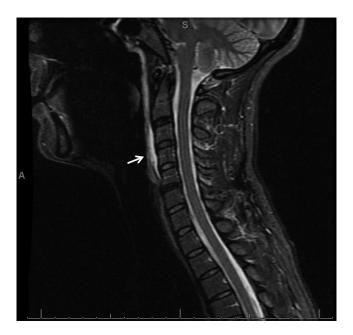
Sagittal STIR view of MRI of cervical spine re-demonstrates prevertebral soft tissue edema from C3 to C5 (white arrow).
